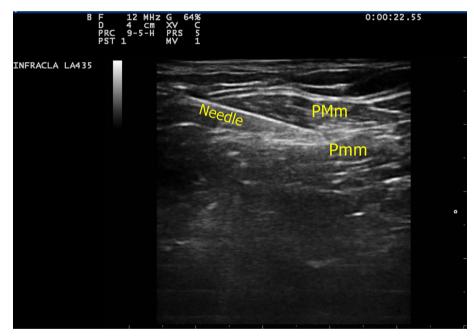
Ultrasound image of needle direction between the muscles
